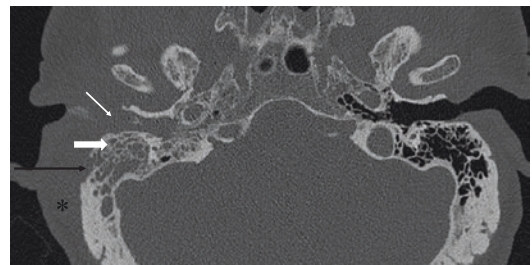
Axial CT bone window showing mucosal thickening occluding the right external auditory canal (thin white arrow) and an opacified mastoid (thick white arrow) with cortical erosion (black arrow) and overlying soft tissue swelling (asterisk)
